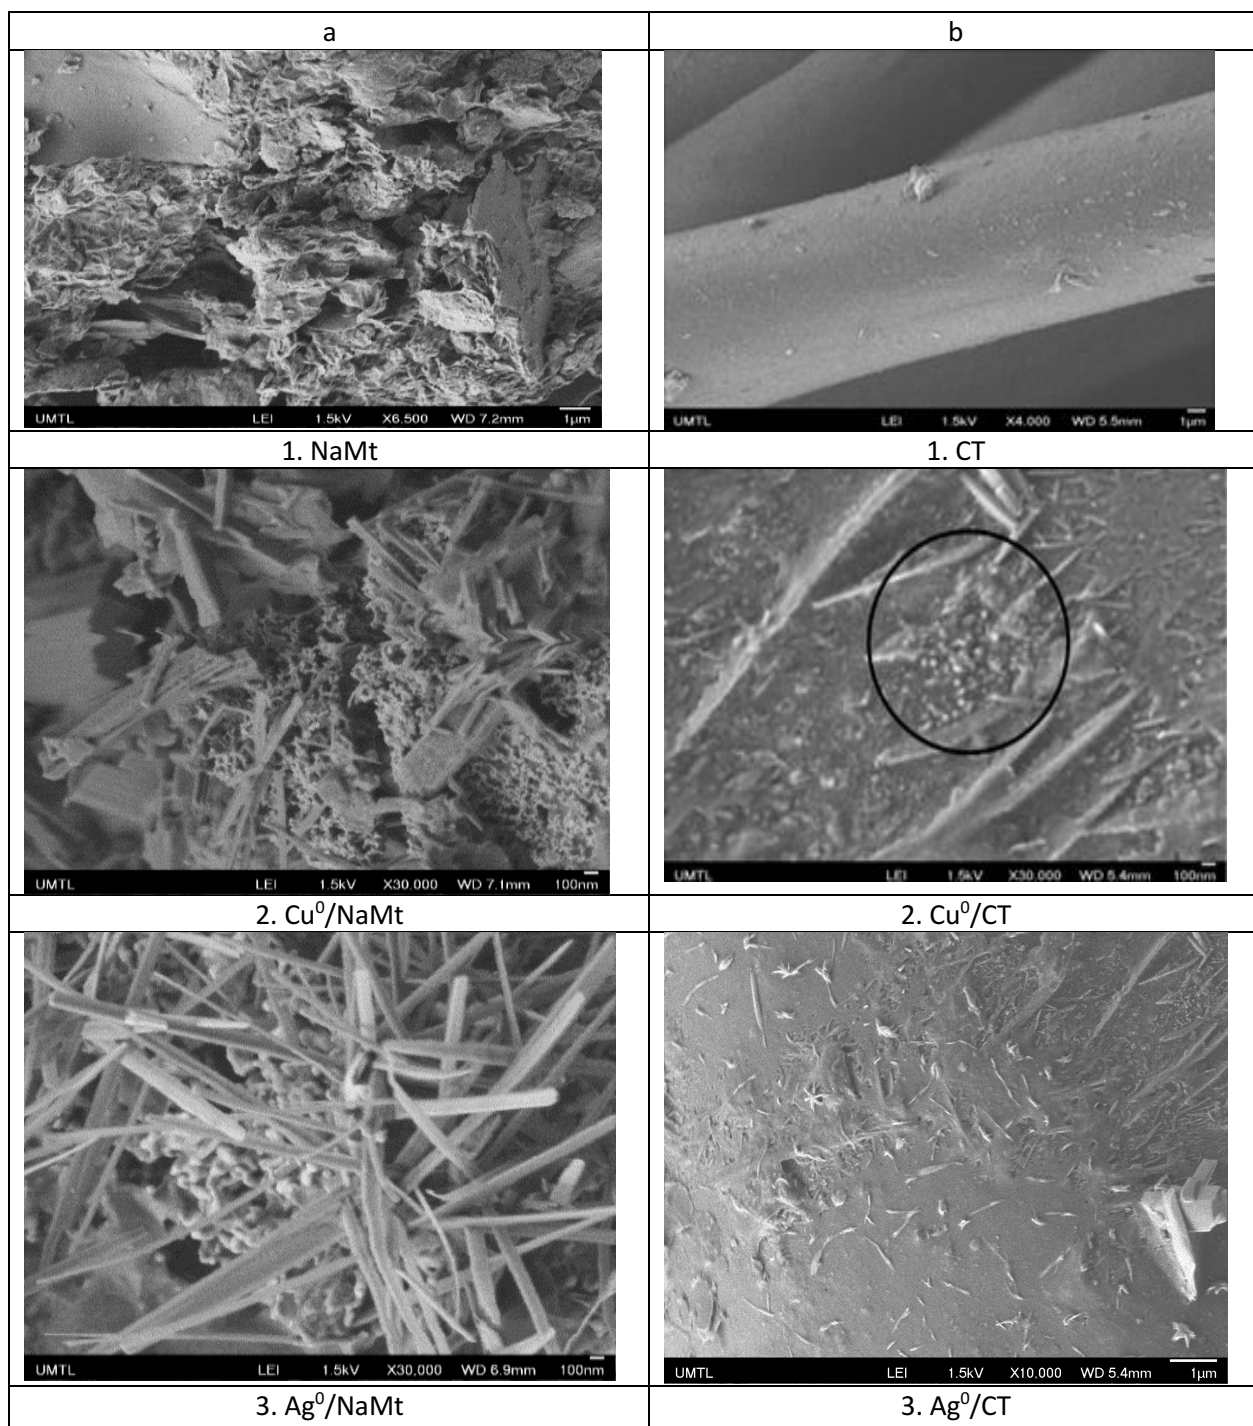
SEM images of NaMt, CT and their metal-loaded counterparts
